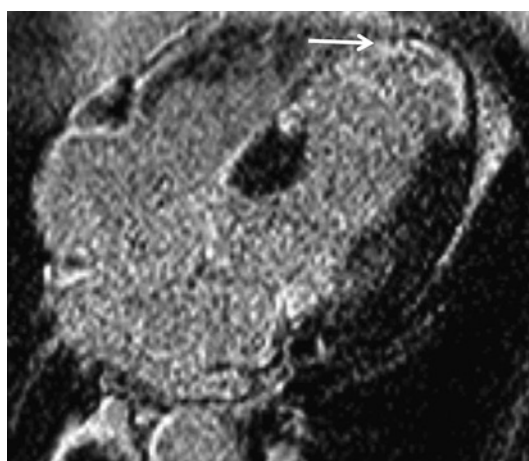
Horizontal long axis late gadolinium cardiac magnetic resonance image demonstrating hyperenhancement (arrow) typical of scar following myocardial infarction. The pattern of enhancement ranges from subendocardial to transmural, and is limited to an arterial territory.
